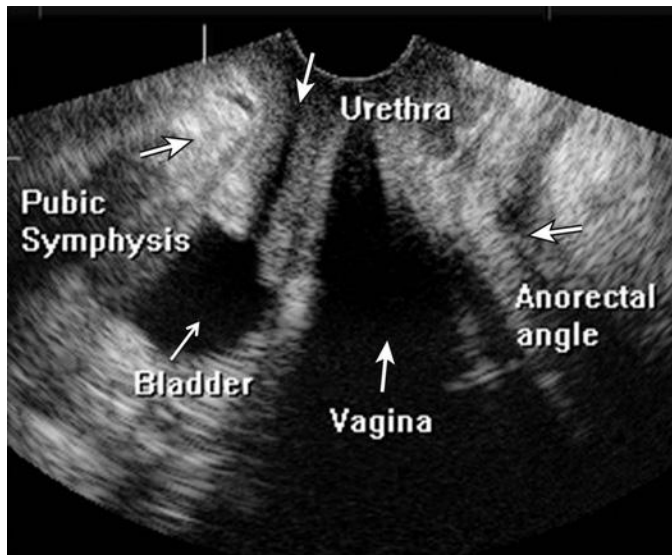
Normal pelvic floor anatomy visualized on the sagittal plane during transperineal ultrasound imaging. Annotated normal sagittal reconstructed image of three-dimensional transperineal ultrasound shows the key structures that are evaluated by this technique. The osseous structures such as the symphysis are echogenic (*white*) whereas the fluid-filled bladder is anechoic (*black*). Gas in the vagina creates posterior shadowing, which may partially obscure structures.
